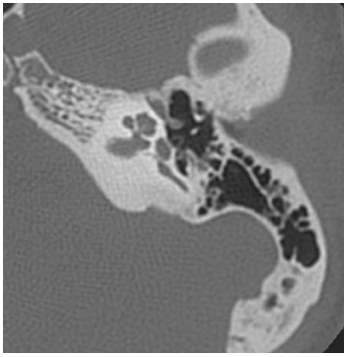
Axial CT images of the petrous bone without findings of otosclerosis in the left ear, of a 49-year-old patient with disease only on the contralateral side. Normal ante fenestram fissula (yellow arrow).
